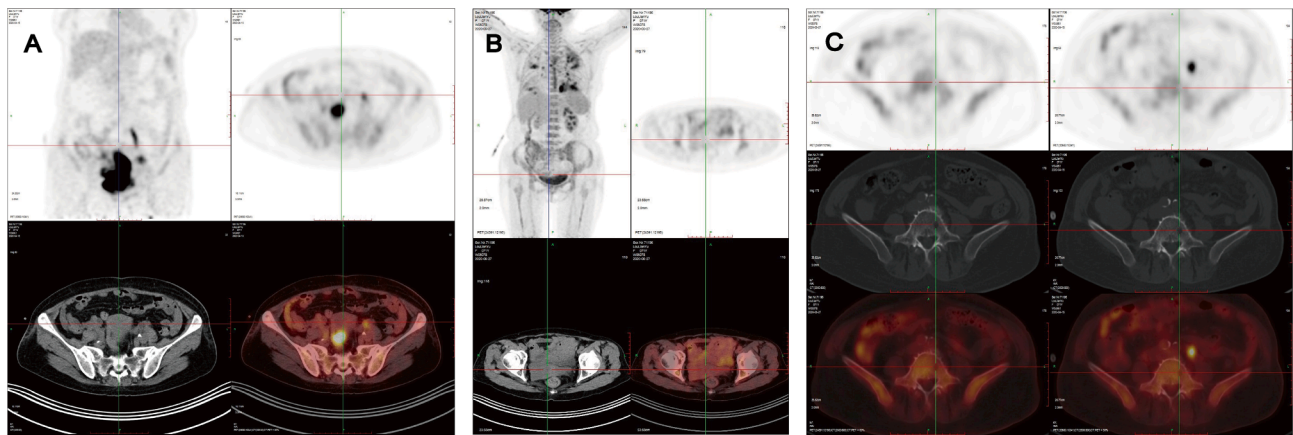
PET-CT imaging. A: Image before treatment. There is a soft bulky mass in the cervix and soft tissue nodules in the bilateral adnexa, compressing the rectum and invading the bladder (triangle). Both are considered malignant with a high likelihood of lymphoma. The retroperitoneal and presacral lymph nodes are involved or metastasized. B and C: Imaging after 2 × R-CHOP. The large soft tissue mass in the cervix and the bilateral soft tissue nodes in the bilateral adnexa have disappeared. Additionally, the hypermetabolic lymph nodes in the retroperitoneal and presacral regions were not detected.
